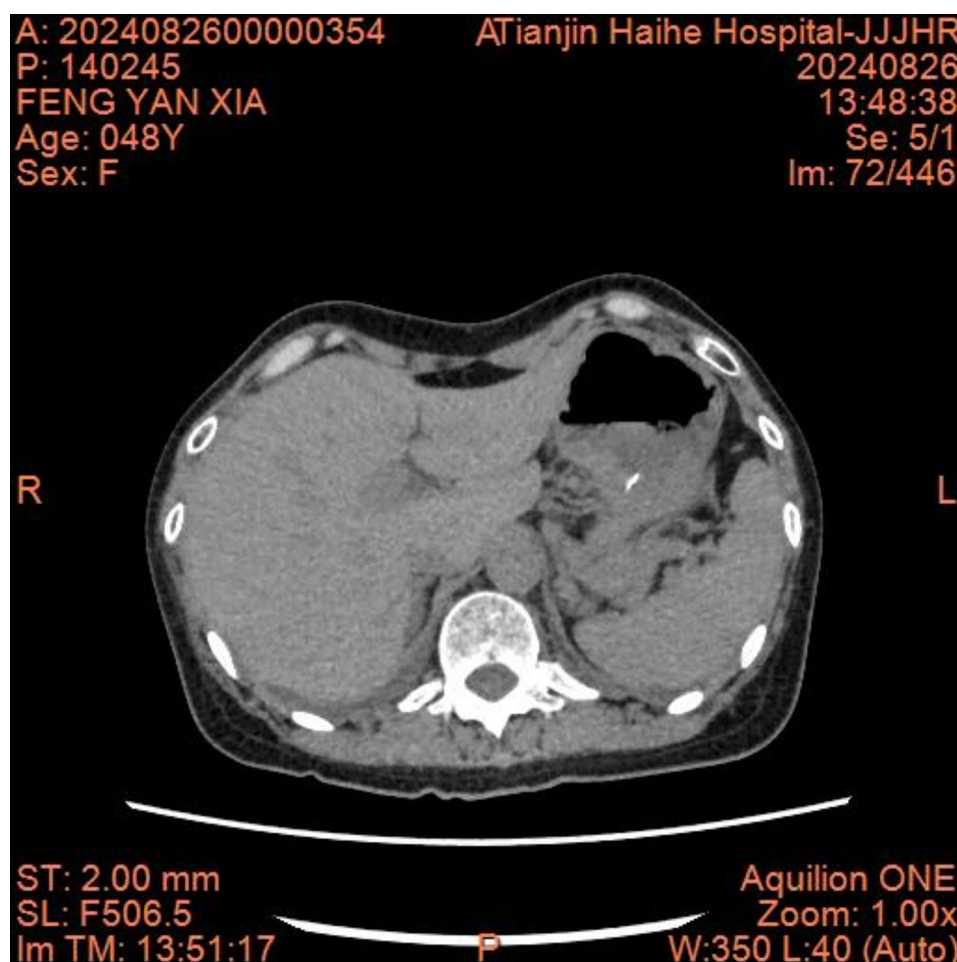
Repeat abdominal CT revealed no residual free air within the peritoneal or retroperitoneal cavities
